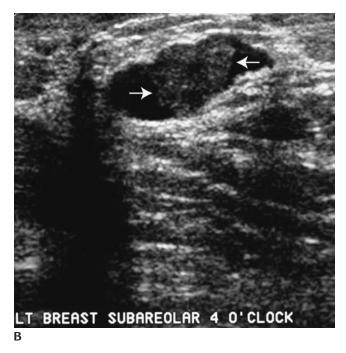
(*Continued*) (B) Intraductal lesion (*arrows*) confirmed on ultrasound. The intraductal (as opposed to intracystic) location of the lesion is determined during the real time portion of the study as the transducer is manipulated over this area. When the lesion is within a duct, the duct elongates and can be seen coming into and out of the scanning plan. With an intracystic lesion, the round or oval shape of the complex cystic mass is maintained as the transducer is rotated and manipulated over the lesion.
